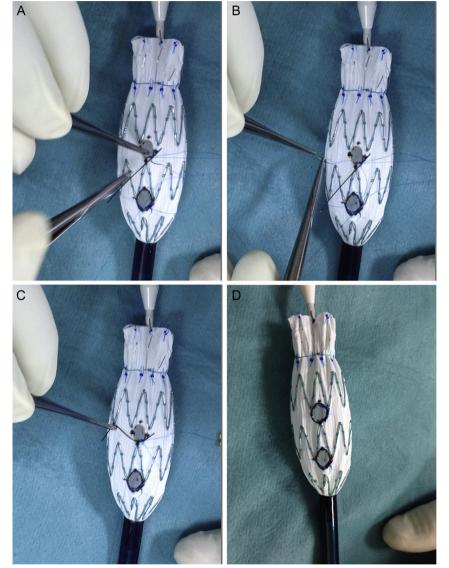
(A,B) Rimming the fenestrations by securing a 0.014 inch soft Command wire (Abbott Vascular) end with prolene 7/0 suture. (C) Molding the wire along the circumference of the fenestration. (D) Wire reinforced fenestrations 8 mm wide 17 mm apart at the 12 o'clock position made on a partially deployed Cook thoracic stent graft based on accurate CT measurements.
